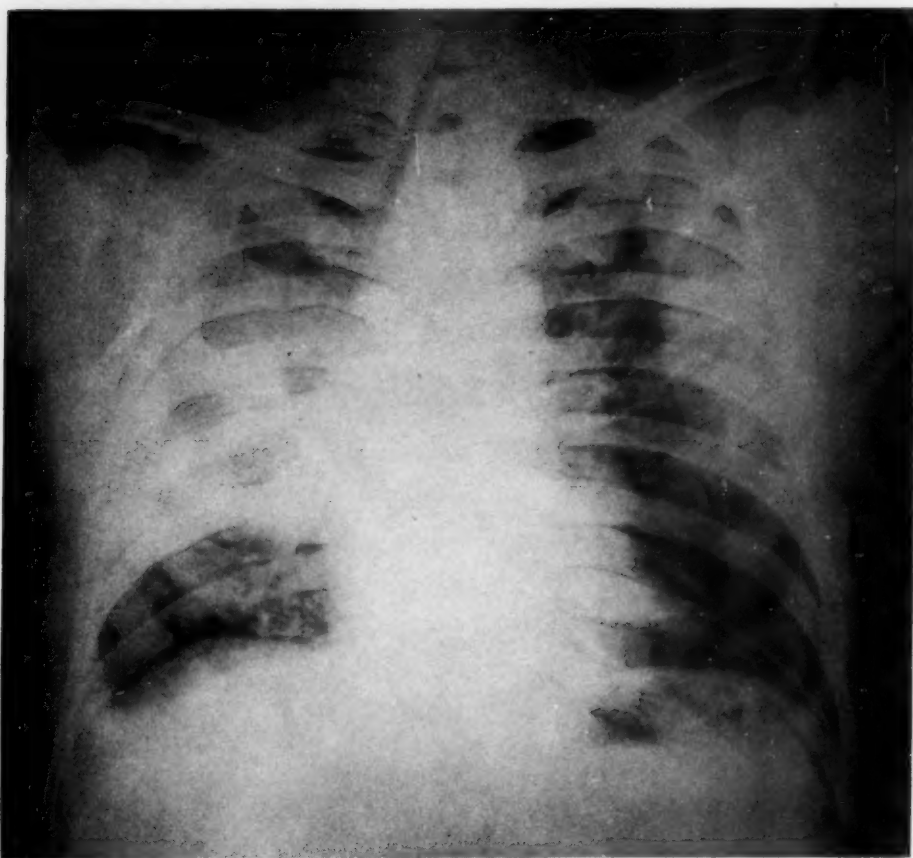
(Case 5.) Roentgenogram taken May 31, 1939. Dense infiltration involving almost the entire right lung. Increase in lung markings throughout the left lung.
